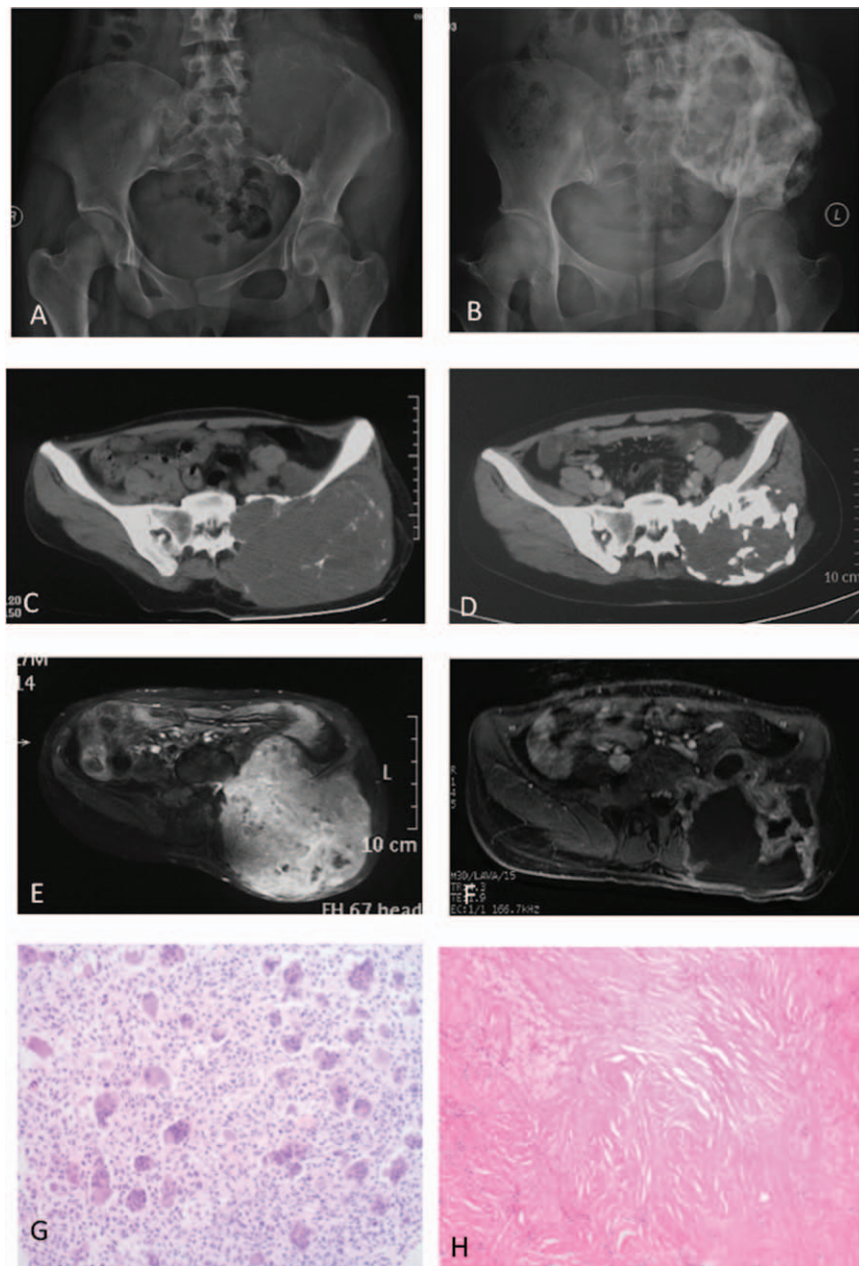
(A–H) A 22-year-old female with left pelvic large GCT. (A) Plain radiograph of the pelvis shows a large lytic lesion with involvement of left ilium and iliosacral joint. (C) Axial CT scan image demonstrates lytic lesion on left pelvis producing large soft tissue mass. (E) The fat-suppressed contrast-enhanced axial T1-weighted image shows significant enhancement. Parallel images obtained following SAEs and denosumab treatment demonstrated significant sclerosis both circumferentially and central part of plain radiograph (B) and axial CT scan (D). The contrast-enhanced image on the T1-weighted image reveals dramatically decreased enhancement. The postdenosumab treated samples are fibro-osseous lesion (H) compares with typical GCT before treatment (G). CT = computed tomography, GCT = giant cell tumor, SAE = serial arterial embolization.
